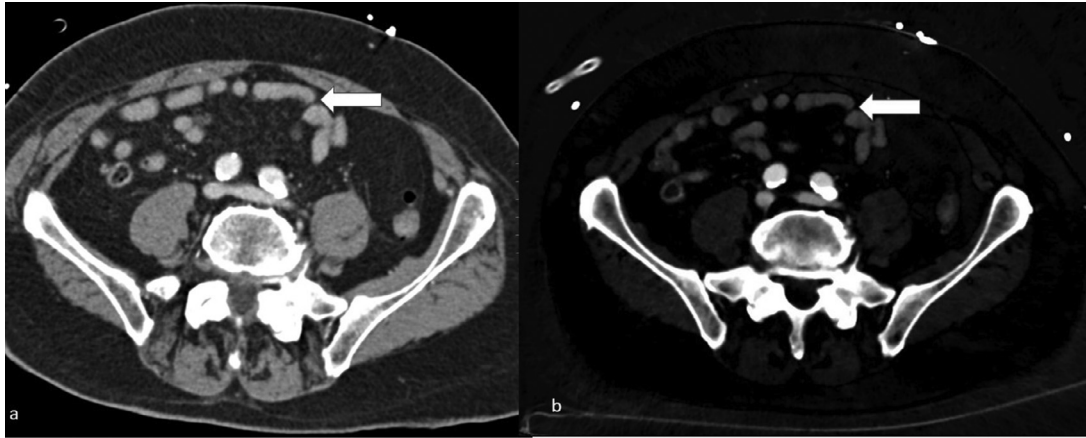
In a slice lower down in the same patient, normal small bowel enhancement (arrows) on contrast enhanced CT (A) and iodine map (B).
